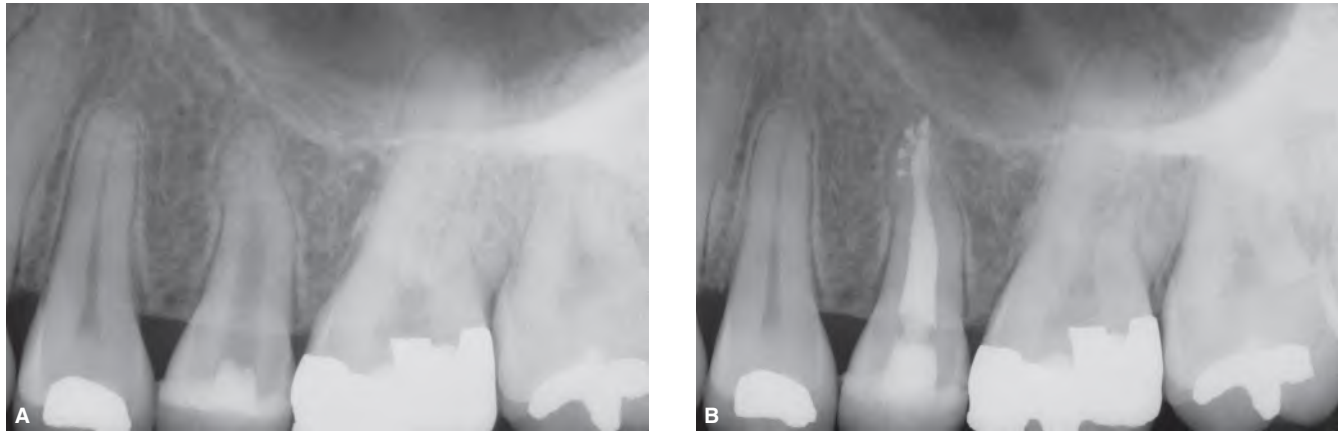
A. A preoperative radiograph of a maxillary left second premolar showing previous access and pre-enlargement of the canal in its coronal two-thirds. B. Postoperative radiograph provides an explanation as to the etiology of the original block. Note, the canal bifurcates apically and has four portals of exit.
